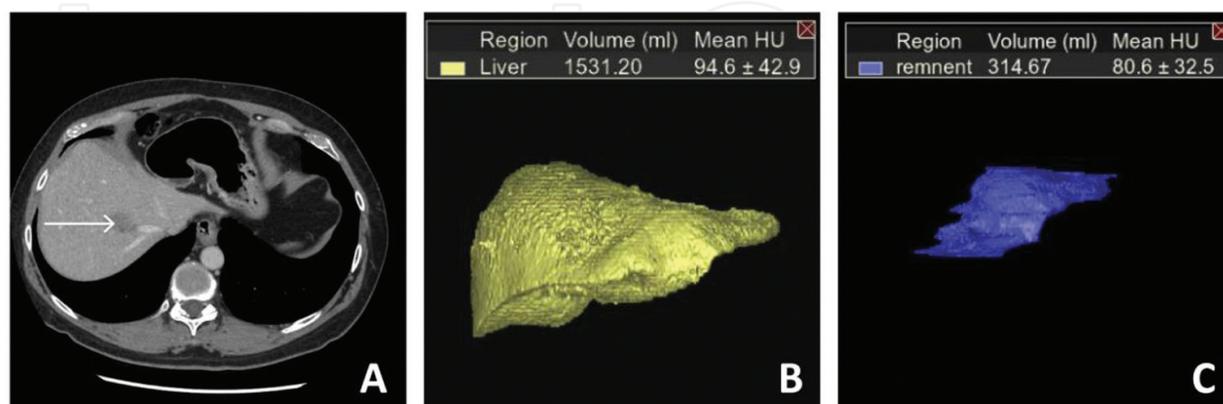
A: Axial CT scan showing solitary colorectal metastasis in segment 8 (arrow) with a congenitally small left lobe. B: Three-dimensional reconstruction and total liver volume (1531.20 ml) measured 6 weeks following right portal vein embolization. C: Three-dimensional reconstruction and total remnant volume (314.67 ml) measured 6 weeks following right portal vein embolization. The left-sided remnant now constitutes 20.5% of the total liver volume and the patient proceeded to right hepatic lobectomy.
